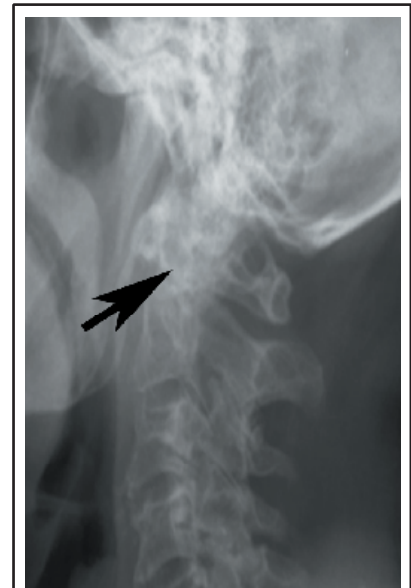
Lateral radiograph demonstrates lytic lesion involving the dens
